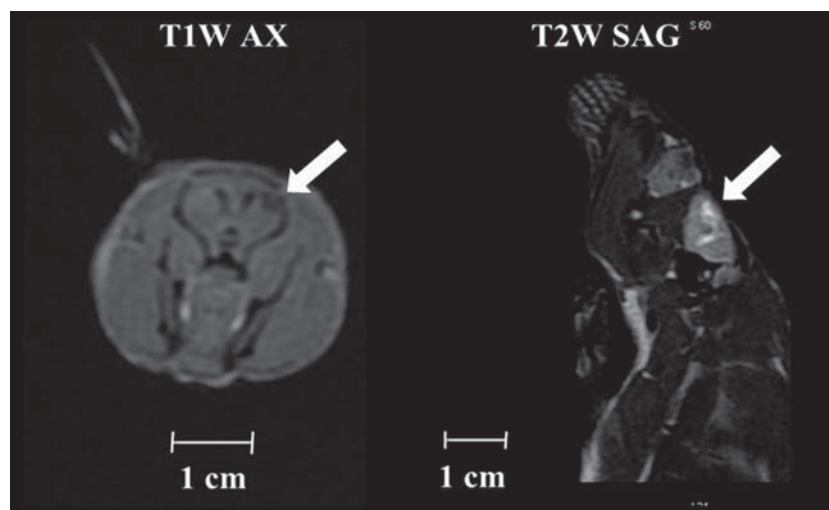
Serial MRI revealed visible structural damage in the form of cavity formation in the cortical region, with extensive perifocal edema, which appeared from 2–4 months following irradiation. Arrows show the place of the radiation injury. The meaning of T1W AX is T1 weighted image of the brain in axial plane and T2W SAG is T2 weighted image of the brain in sagittal plane.
